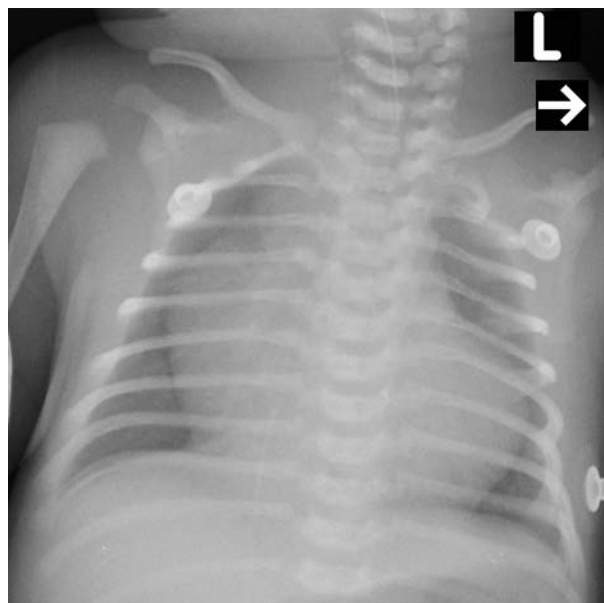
The first day of life. Chest radiograph shows significant cardiomegaly. Vascularity of the pulmonary fields is not visible
